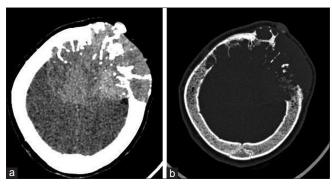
(a) Noncontrast computed tomography head showing large hyperdense extra-axial lesion over midline frontoparietal region. (b) Noncontrast computed tomography head (bone window) showing erosion of the skull
